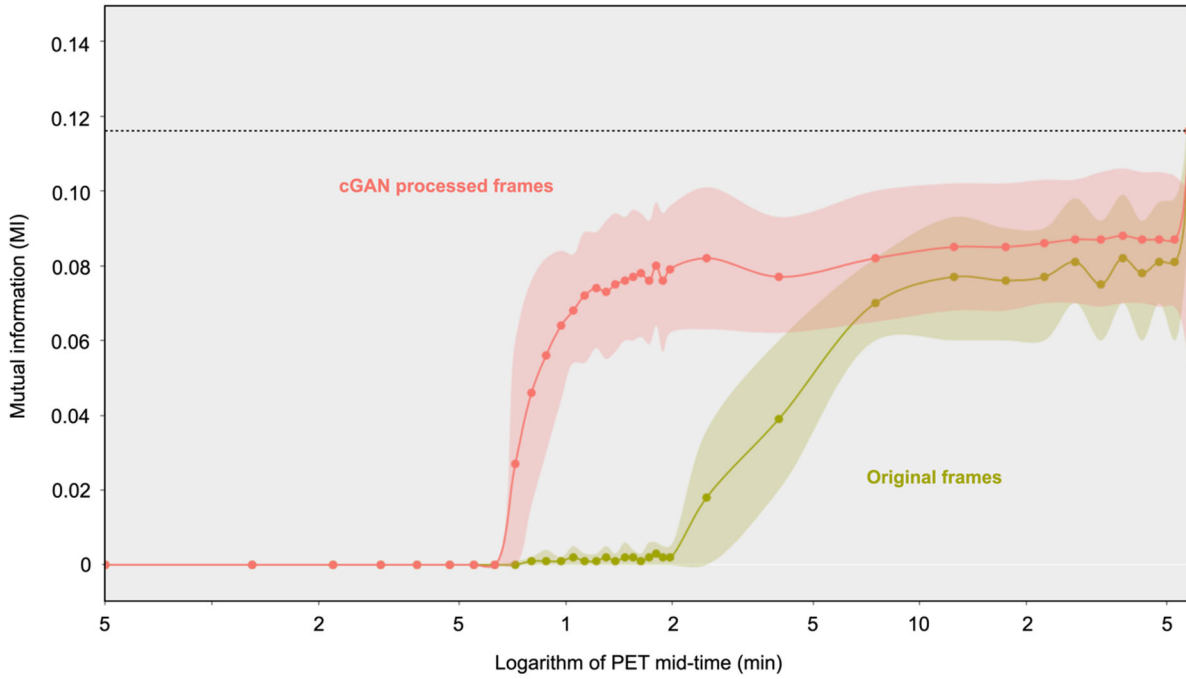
Comparison of mutual information index (MI) between the original (green) and cGAN processed (red) dynamic frames with the reference frame as a (log) function of scan time. Note that neither dynamic sequence is motion corrected. Values represent the average and the std. dev. (shown as shaded area) of the test data set (N = 6). cGAN processing increases mutual information of 18F-FDG brain images with respect to the reference frame close to the mutual information of late frames (dotted line).
